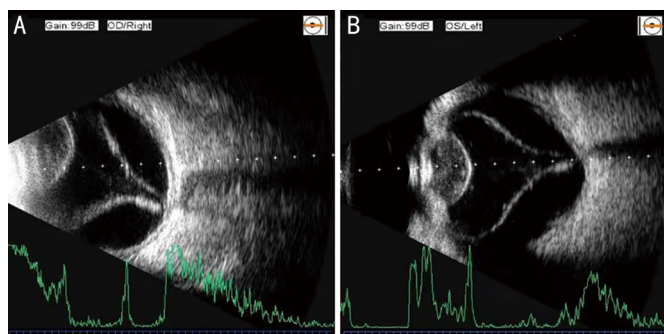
Misdiagnosed case of RD A: RD combined with anterior vitreous opacity by conventional B-ultrasound diagnosis; B: RD combined with lens swelling opacity by Pano-immersion B-scan ultrasonography. RD: Retinal detachment.
